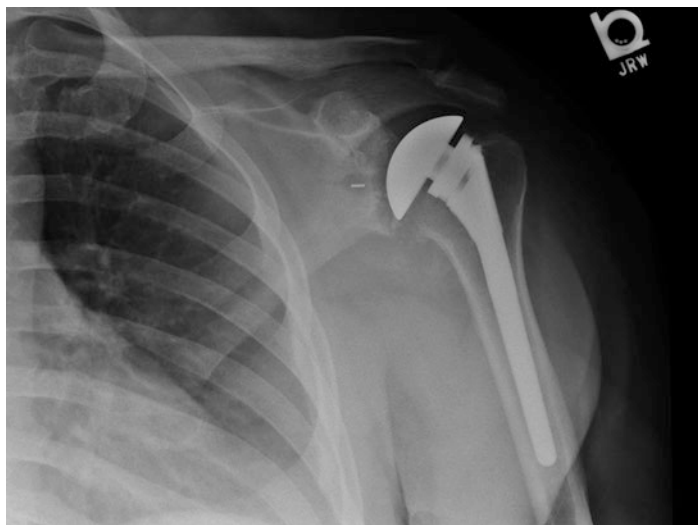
AP radiograph showing total shoulder arthroplasty with posterior augmented glenoid
